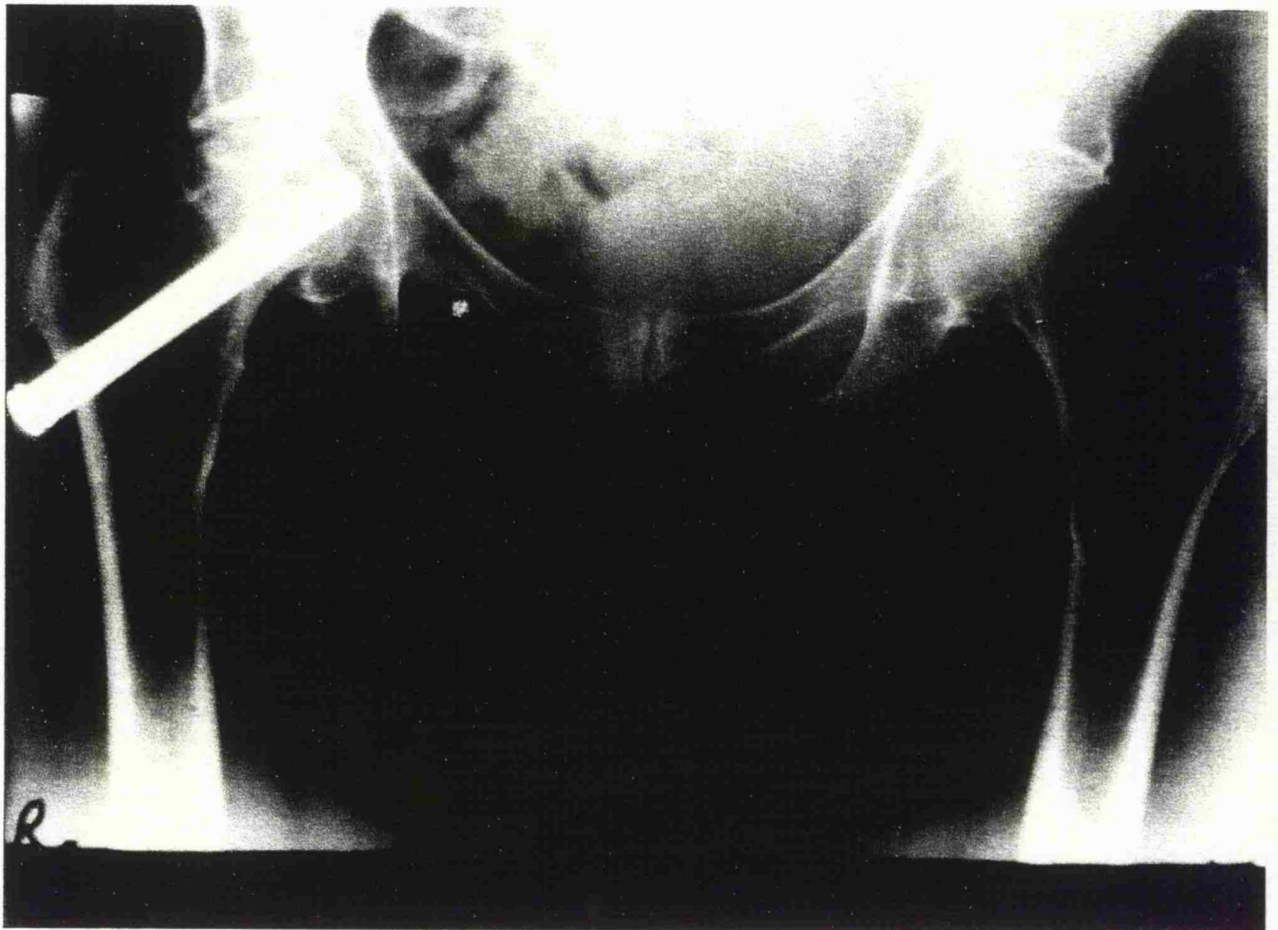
An antero-posterior radiograph of an intracapsular fracture internally fixed with a single nail.
